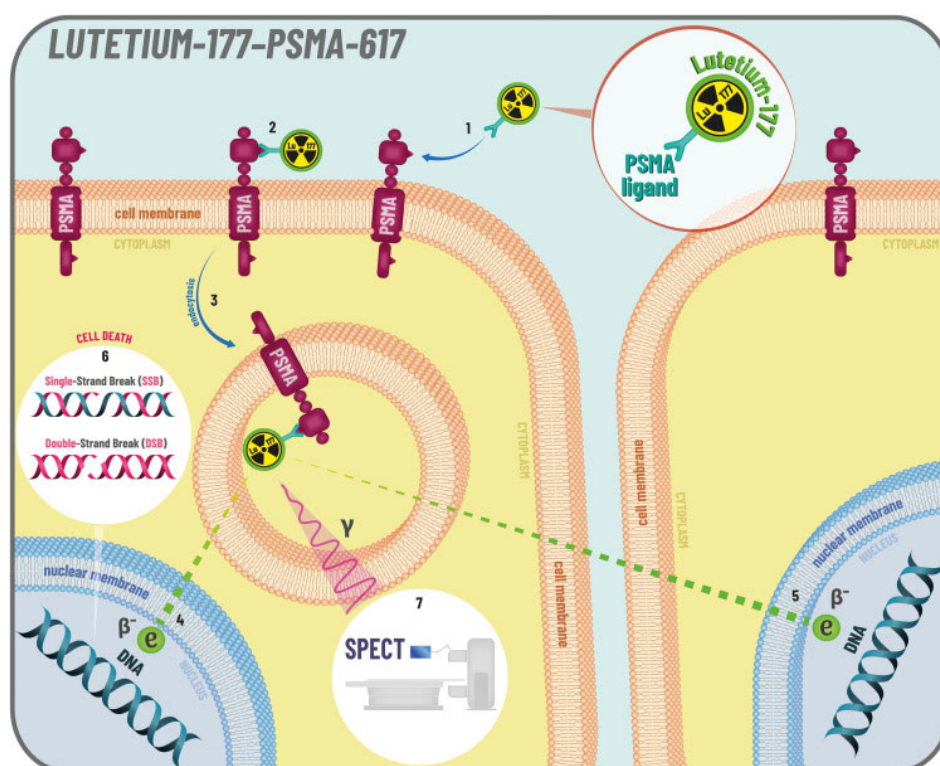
Mechanism of action of lutetium-117-PSMA-617, a radioligand used for diagnosis and treatment (Ferretti et al., 2023).
